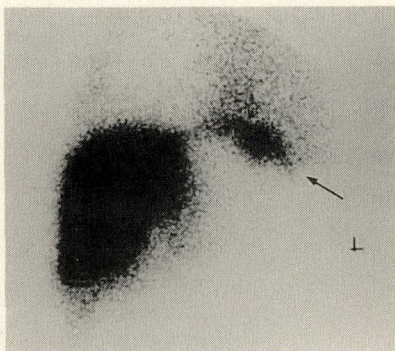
Image obtained from technetium-99m sulfur colloid scintigraphy on day after subtotal splenectomy and portal-variceal disconnection demonstrates viability of liver and spleen (arrow).
